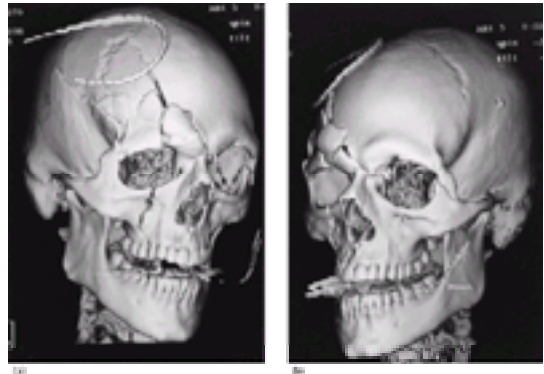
Three-dimensional CT scans demonstrating asymmetrical craniofacial fractures. Left Le Fort III fracture and right zygomatico-orbito-frontal fracture.
